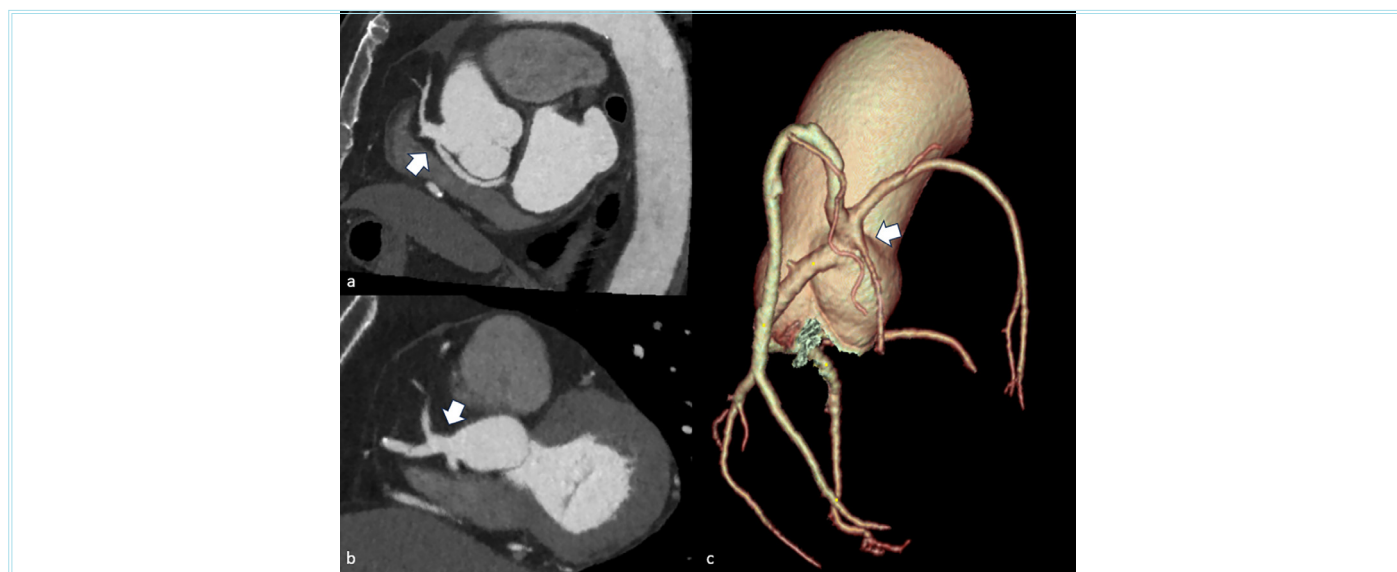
The patient has a single coronary ostium anomaly. (a, b) Sagittal reformatted CT angiography and (c) 3D volume-rendered CT images demonstrate all coronary arteries originating from a single ostium located in the right coronary sinus (white arrows)
